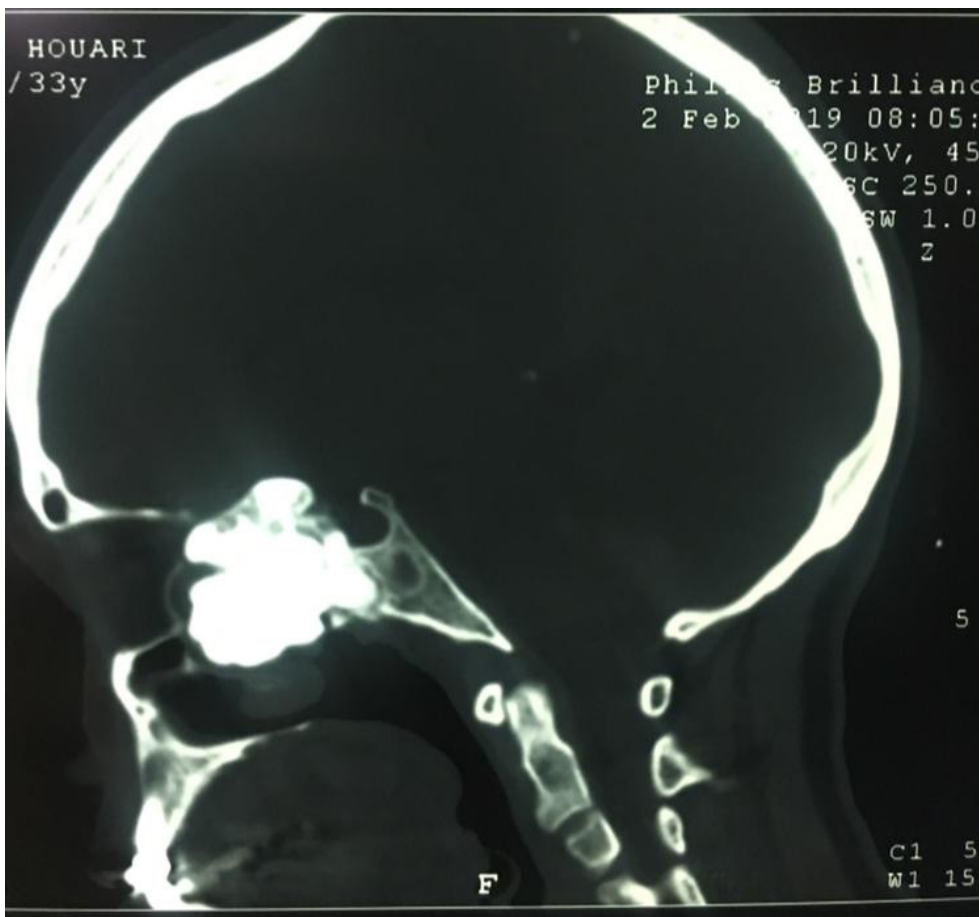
Computed tomography of face, sagittal cut, radiopaque lesion, occupying the right ethmoidal sinus
